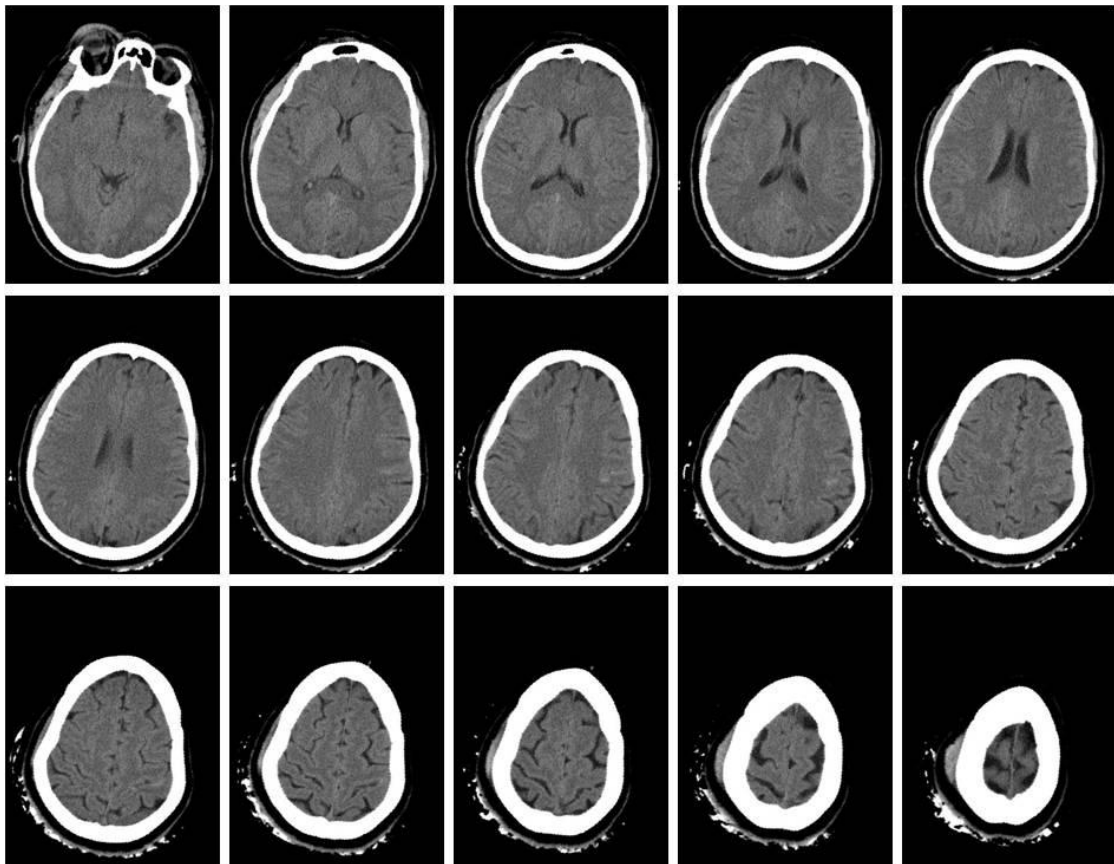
Selected CT slices after the closed skull inspection
